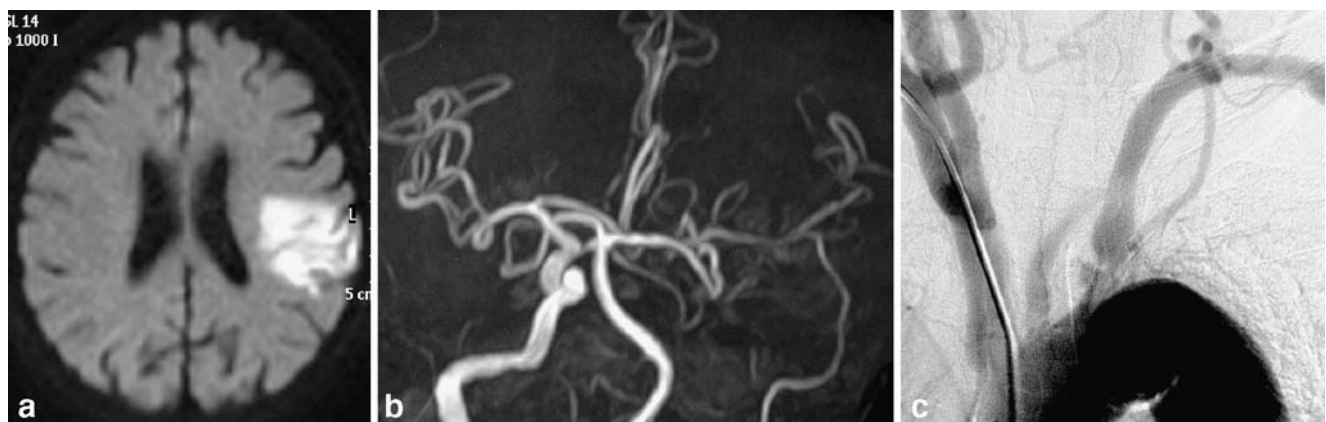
High-intensity area in the middle cerebral artery region is revealed on DWI obtained on admission (a). The left ICA is not seen on MR angiography (b). Occlusion of the CCA is seen on the angiogram (c)
